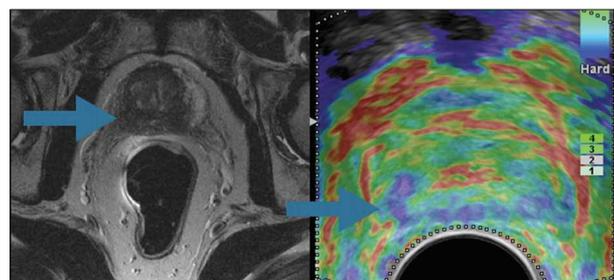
T2-weighted endorectal magnetic resonance imaging and real-time sonoelastography in a patient with prostate cancer (Gleason score, 7) in the left apex. Axial magnetic resonance imaging shows an area of low signal intensity in the left apex, and sonoelastography shows a hard area in the same location (arrows).
